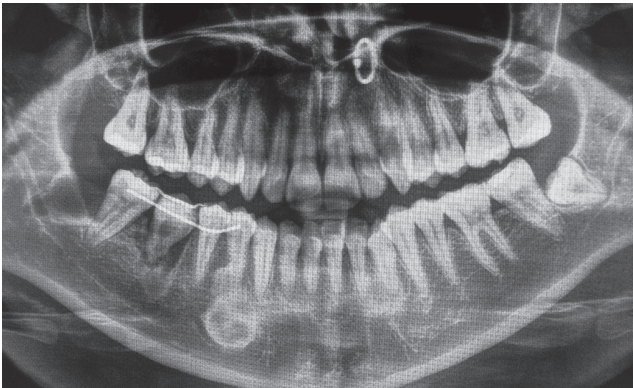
Panoramic radiograph of the patient after autotransplantation of right mandibular third molar. The tooth was stabilized with a wire splint to optimize reattachment
